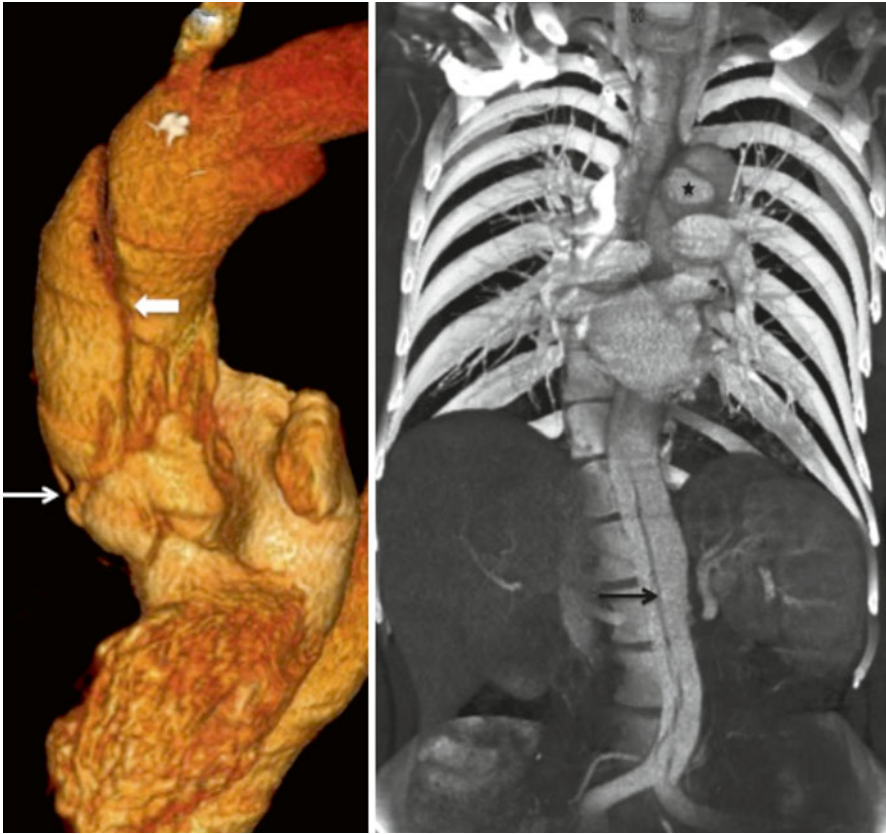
Volume rendered CT images in two patients with type A (*left panel*) and Type B (*right panel*) dissection. In the first patient, the dissection flap in the ascending aorta (*block white arrow*) involves the ostium of right coronary artery (*thin white arrow*). In the second patient, the dissection involves the descending and abdominal aorta down to the bifurcation (*black arrow*). The true lumen in the descending thoracic aorta (*black star*) is smaller and shows better enhancement whilst in the abdominal aorta the differential enhancement between the two lumina is less evident
